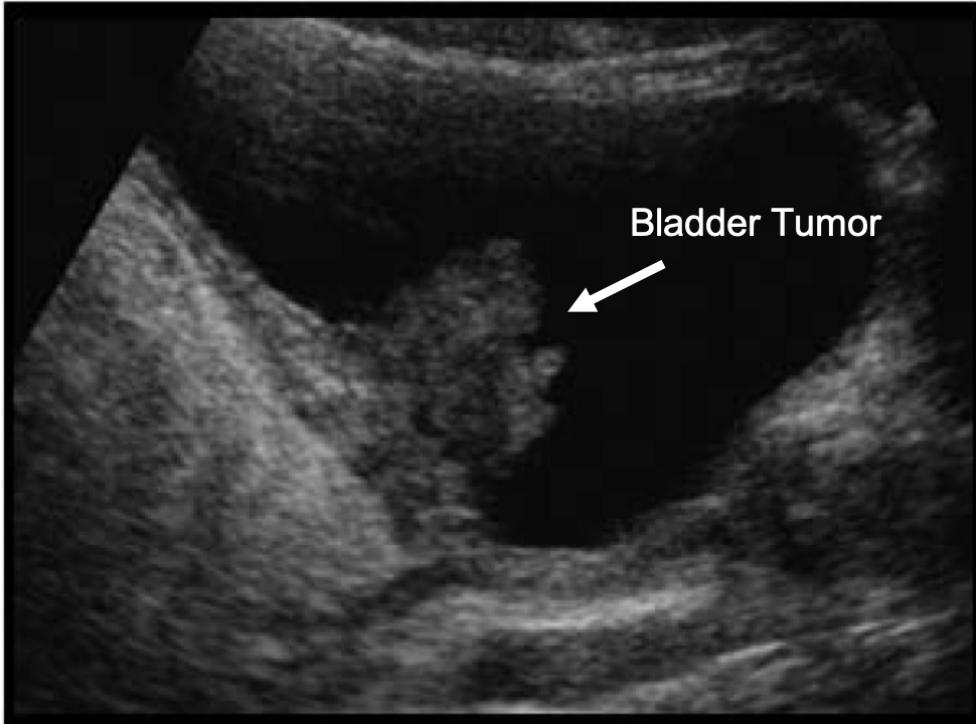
Bladder Tumor. On this bladder ultrasound, a large bladder tumor is visualized as a mass projecting into the bladder lumen.
